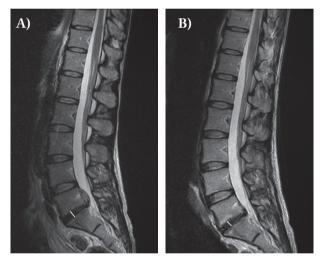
Sagittal T2 image at MRI evaluation of maximum thickness of disc in a 39-year-old woman with a large migrated herniation at L5-S1 (A. pre coblation; B. post coblation)
